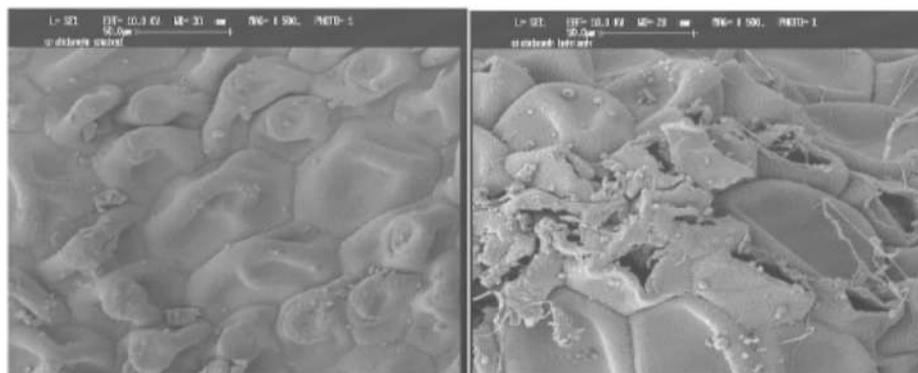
SEM images of a black cumin seed structure 1) without ultrasound treatment and 2) with ultrasound treatment (Moghimi et al. (2018)).
